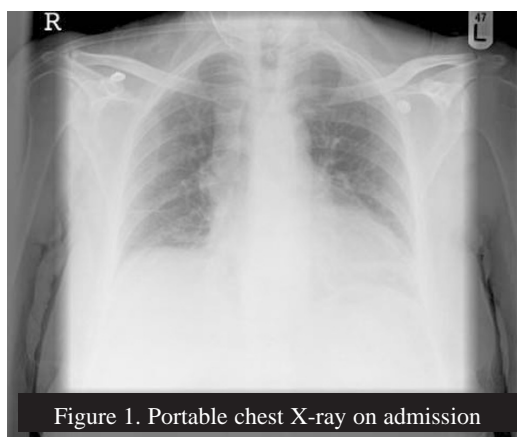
Portable chest X-ray on admission
